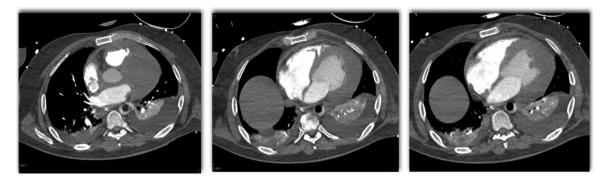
Thickening of the left ventricular myocardium seen on axial chest CT images.
